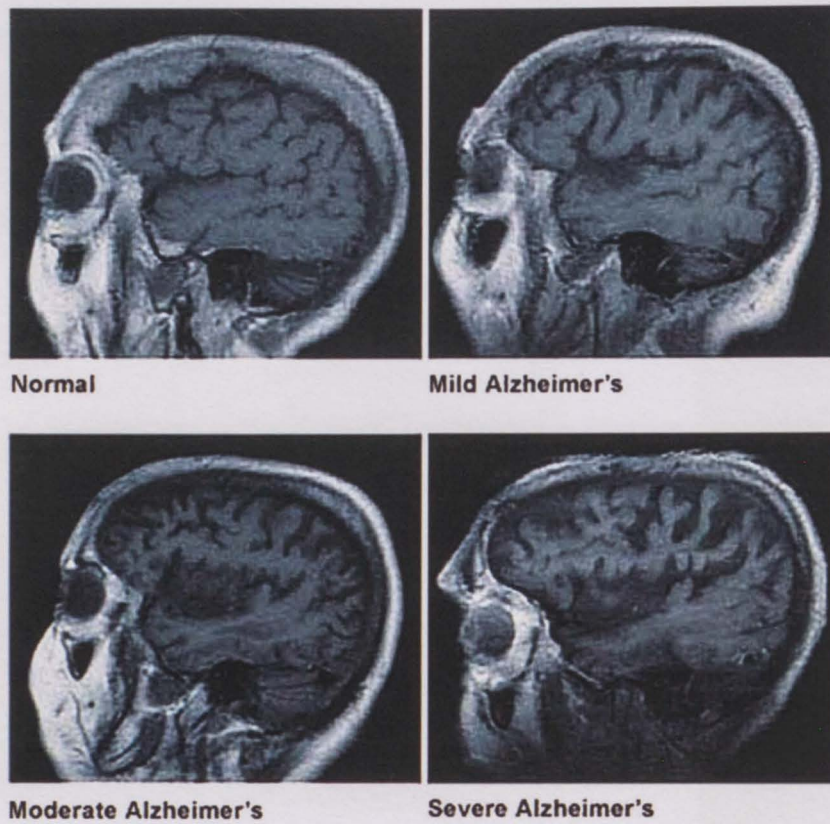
Magnetic Resonance Images presenting four different people with differently sized and shaped brains. The spreading grooves and fissures of the cerebral cortex indicate progressively severe brain atrophy and loss of brain mass, characteristic of Alzheimer's disease. Source: Mayo Foundation for Medical Education and Research, (1998-2012).
